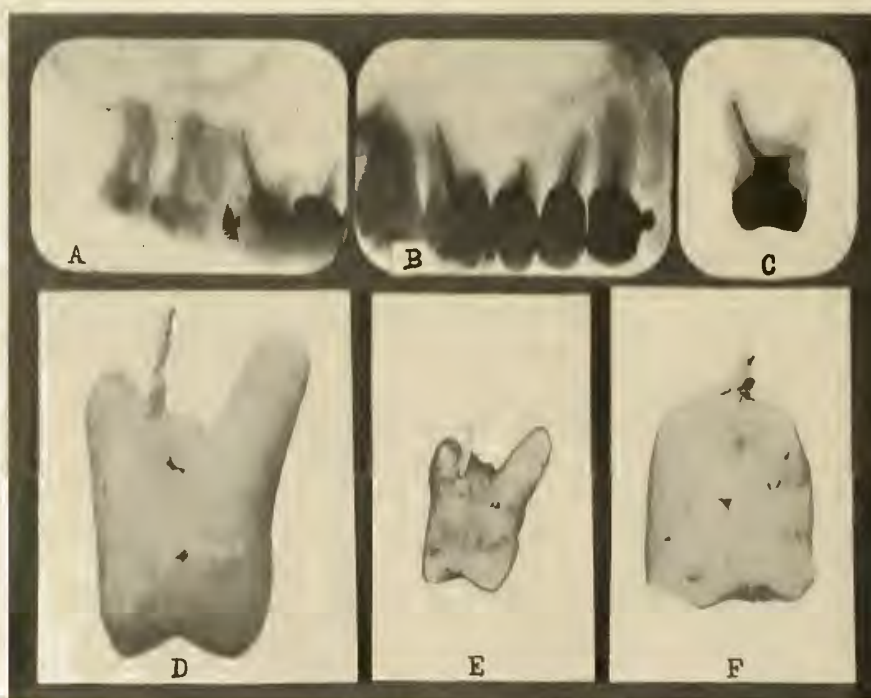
COMPARISON OF ROENTGENOGRAPHIC VIEW OF TEETH WITH THE PHOTOGRAPHS OF SAME WHEN EXTRACTED.
